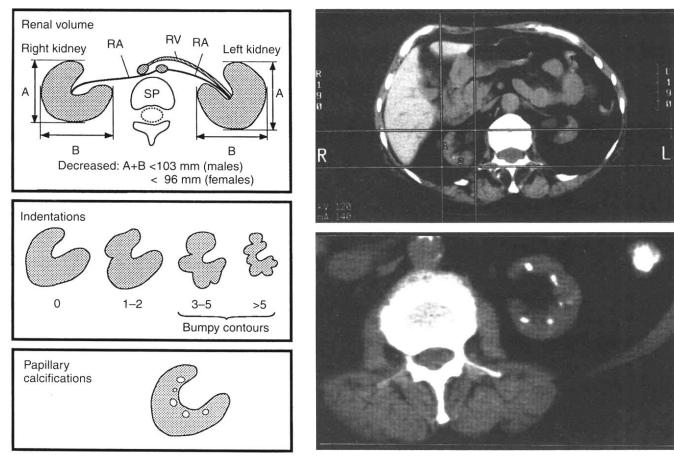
Description of the renal imaging criteria of analgesic nephropathy as observed on CT scan including a decreased renal volume, bumpy contours and papillary calcifications. Renal size was measured by the sum of both sides of the rectangle enclosing the kidney at the level of the renal vessels. Indentations were counted at the level where most indentations were present. Triangular, ringlike or polygonic calcifications on the papillary line were considered as signs of renal papillary necrosis.
